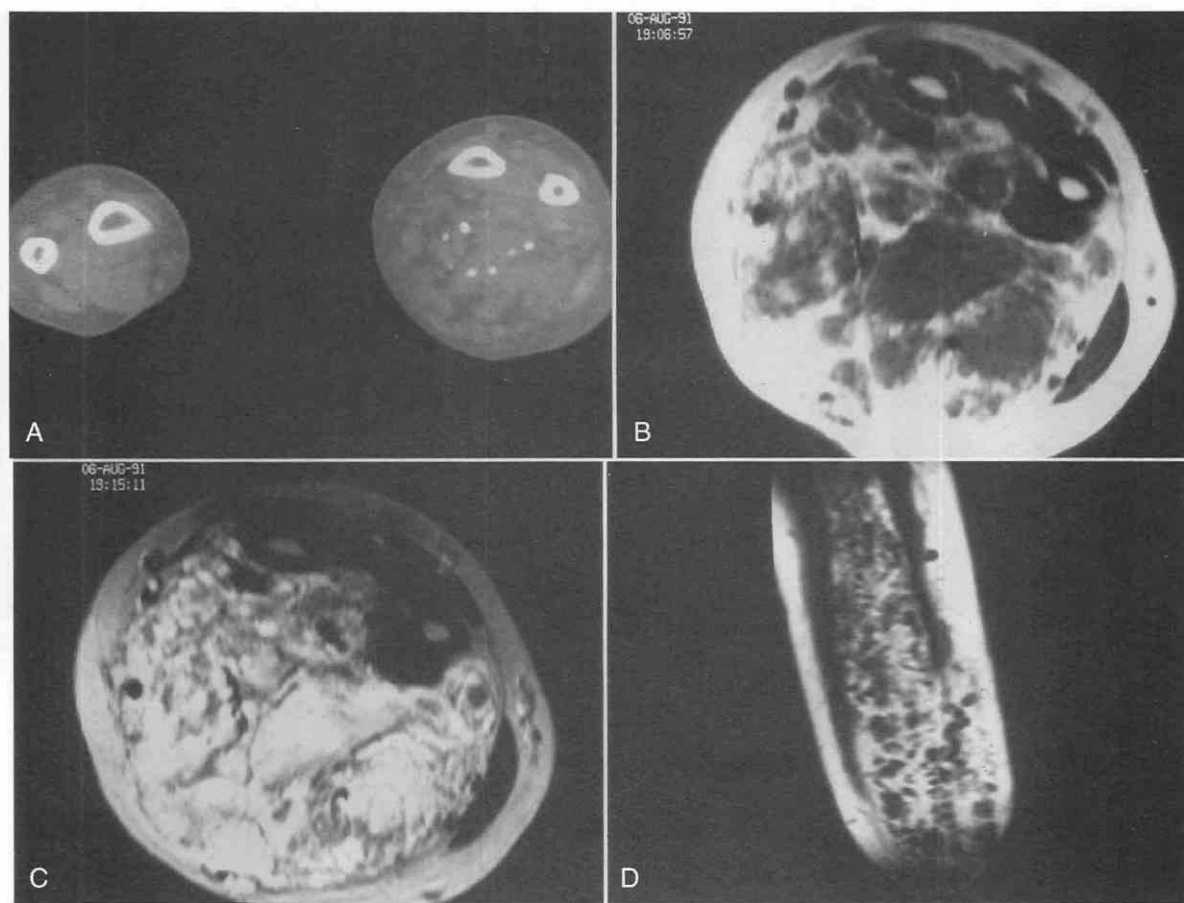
Hemangioma. A, CT scan shows multiple phleboliths in the forearm within a soft tissue mass. B, T1-weighted image shows the lesion to be isointense with muscle; an area that shows increased signal intensity corresponds to fat interposed between vascular elements. C, T2-weighted image shows vascular elements of high signal intensity. D, Coronal T1-weighted image shows large tortuous vessels with flow void caused by rapidly flowing blood.
